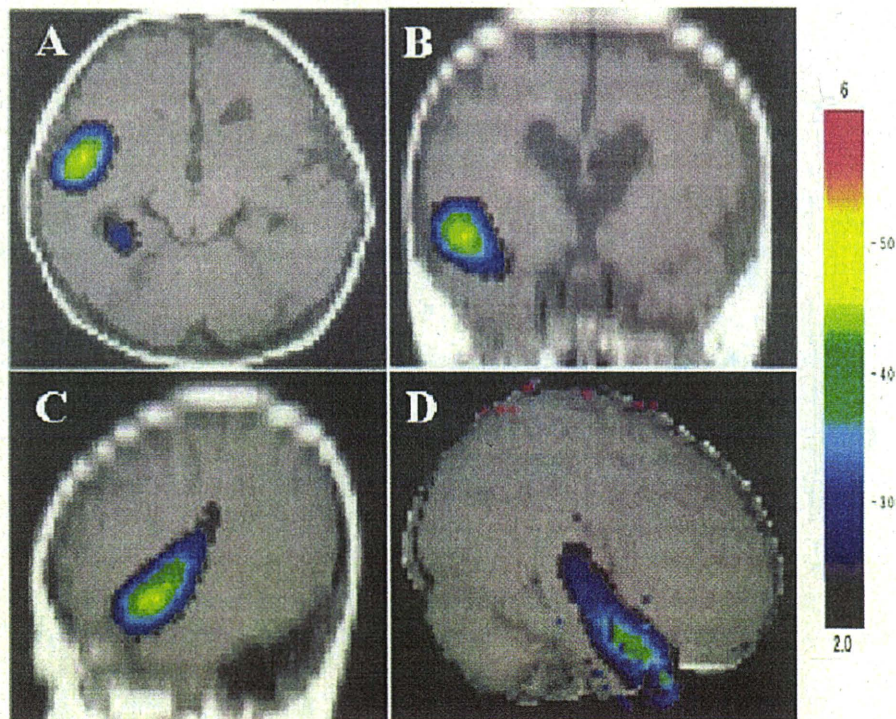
Subtraction ictal single-photon emission computed tomography (SPECT) coregistered to magnetic resonance (MR) imaging (SISCOM)
